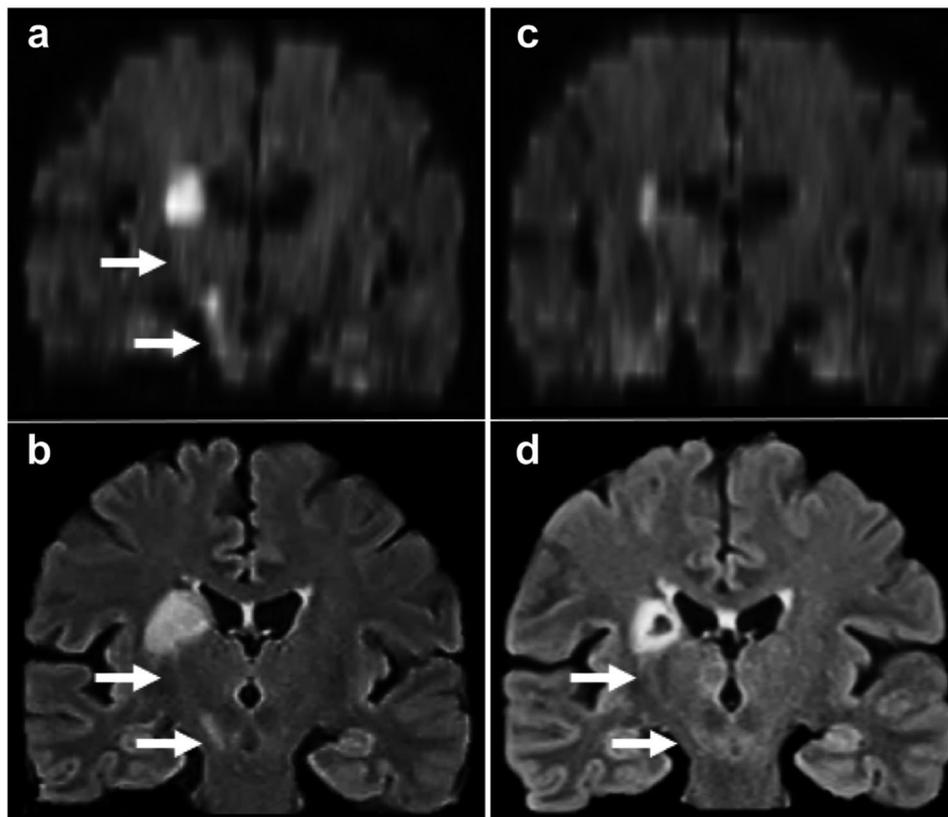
Long-term follow-up MRI scan and tracking of changes on DWI and FLAIR imaging. A 65-year-old woman underwent axial follow-up magnetic resonance imaging (MRI), including diffusion-weighted imaging (DWI) and coronal fluid-attenuated inversion recovery (FLAIR) imaging during the acute and chronic phases of stroke. The second coronal DWI (a) and coronal FLAIR (b) were obtained 9 days after stroke onset. Each sequence demonstrates a high signal in the pyramidal tract descending from the infarction. The third DWI (c) and FLAIR (d) were performed 48 days after onset. The high DWI signal disappeared, and the high FLAIR signal is more defined. All coronal DWI images (a and c) were created using multiplanar reconstruction
